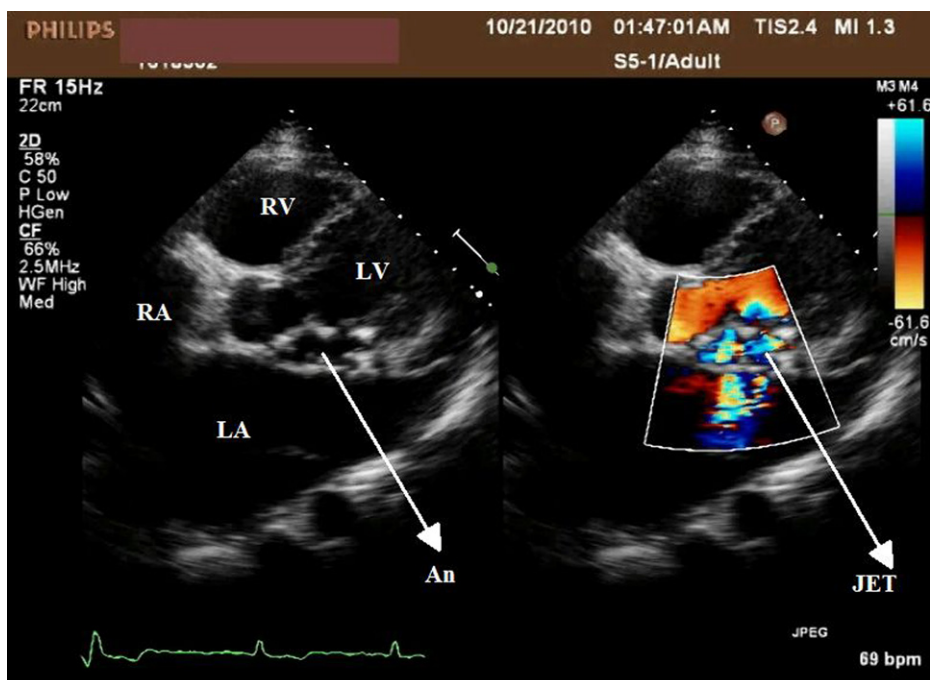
Transthoracic echocardiography with modified five chamber view showing pseudo-aneurysm between anterior mitral leaflet and noncoronary cusp of the aortic valve. On color doppler there is evidence of communication of pseudo-aneurysm with left atrium and left ventricle. Calcification of the wall of pseudo-aneurysm suggests chronicity of the condition. LV = Left ventricle, LA = Left atrium, RV = Right ventricle, RA = Right atrium.
